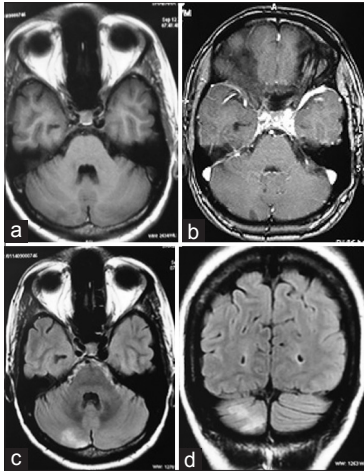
Magnetic resonance imaging of brain showing hypointense lesion in the right cerebellar hemisphere on T1-weighted images (a), which does not show postgadolinium enhancement (b), hyperintense on fluid-attenuated inversion recovery axial (c), and coronal (d) sequences
